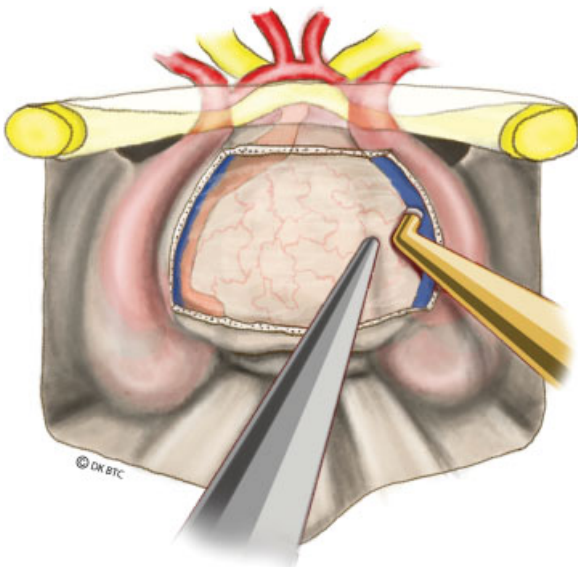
Artist representation of micro-Doppler usage for localization of the cavernous carotid arteries.
